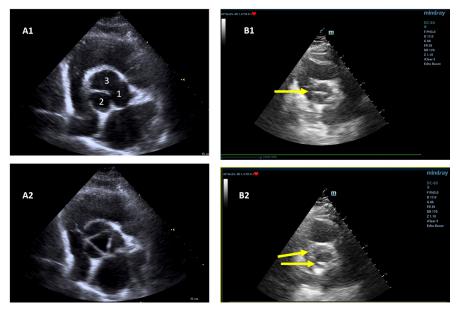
b.1. Normal aortic valve with 3 cusps (A1: closed normal aortic valve; 1-left coronary cusp, 2-right coronary cusp, 3-non-coronary cusp; A2: opened normal aortic valve, with a triangular appearance of the orifice) and congenital bicuspid aortic valve (B1: closed bicuspid aortic valve, with horizontal raphe; B2: opened bicuspid aortic valve with oval appearance of the orifice); (parasternal short axis view at the level of the great vessels).
